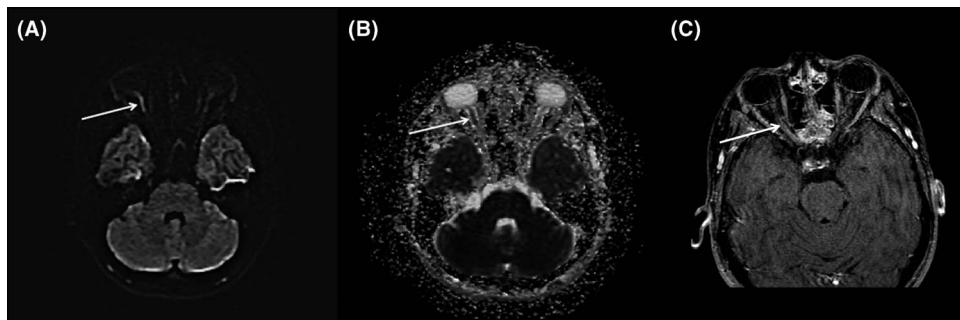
MRI of the optic nerves. (A) Axial diffusion weighted imaging shows increased restriction in the optic nerves, right (arrow) more than left; (B) Axial apparent diffusion coefficient map showing a corresponding dark appearance (arrow), in keeping with true diffusion restriction; (C) Axial gadolinium-enhanced fat-suppressed T1-weighted imaging showing subtle contrast enhancement of the right optic nerve (arrow), consistent with inflammation.
